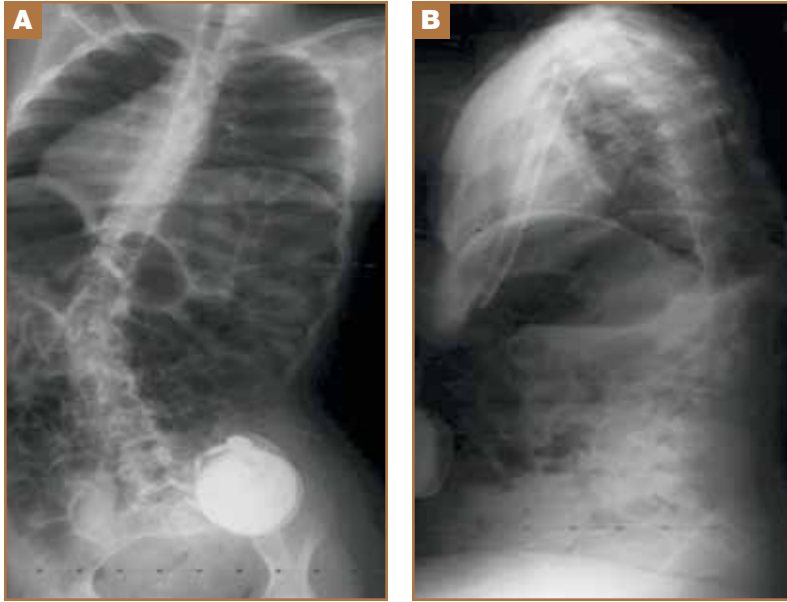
Seventeen-year-old adolescent girl with traumatic brain injury and progressive neuromuscular scoliosis. Preoperative posteroanterior (A) and lateral (B) radiographs show apex left thoracolumbar curve. Intrathecal baclofen pump is also visualized.
